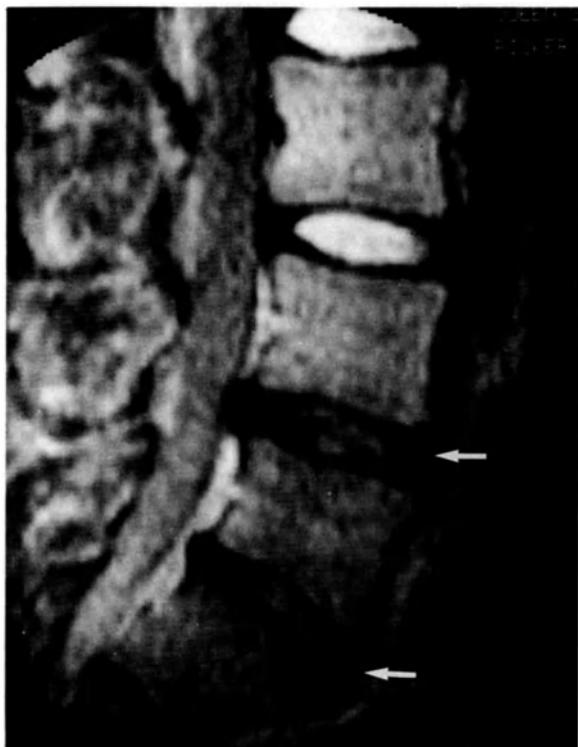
Sagittal MRI, T<sub>2</sub>-weighted image (2000/80). The L4–5 and L5–S1 intervertebral discs show disruption of the horizontal lamina and markedly reduced signal. The annulus fibrosis of each bulges into the spinal canal, and that of L4–5 causes minimal indentation of the spinal theca.
